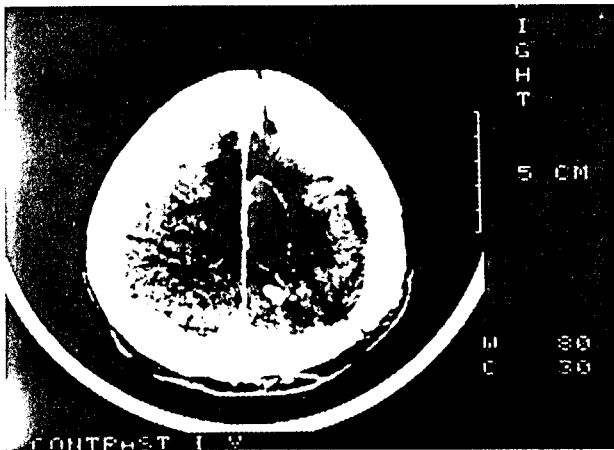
Postcontrast CT scan revealed a large ring-extending abscess to the high convexity right frontoparietal area. A foreign body (bone fragment is also seen (Case 3).
